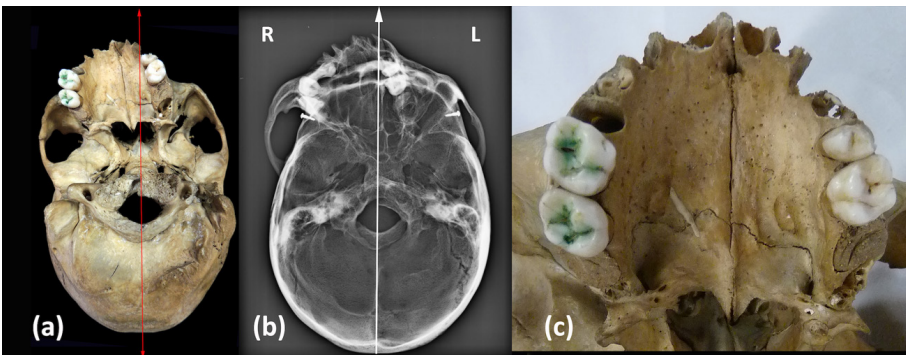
a) Inferior view (red line, sagittal plane); b) Inferior view, X-Ray image (white line, sagittal plane); c) Maxillary and palatal bones, inferior view.
